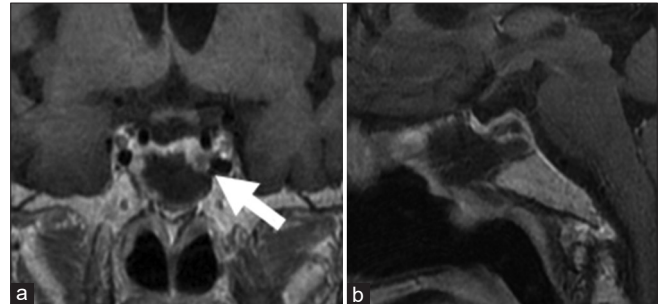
(a) Magnetic resonance imaging (MRI) coronal section postoperative MRI reveals a complete removal of the macro pituitary neuroendocrine tumor (PitNET) and the residual micro PitNET (arrow) in the left thin, normal pituitary gland. (b) MRI sagittal section postoperative MRI reveals a complete removal of the macro PitNET.
